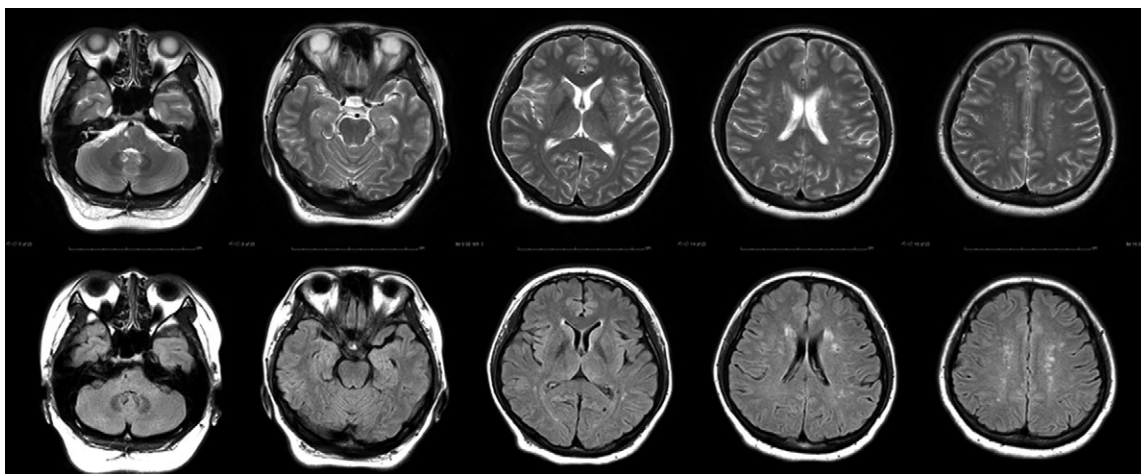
Pre-pregnant axial sections of T2-weighted image (upper row) and fluid attenuation inversion recovery (lower row) show a small infarction scar in the right medulla oblongata and mild leukoaraiosis in the cerebral white matter.
